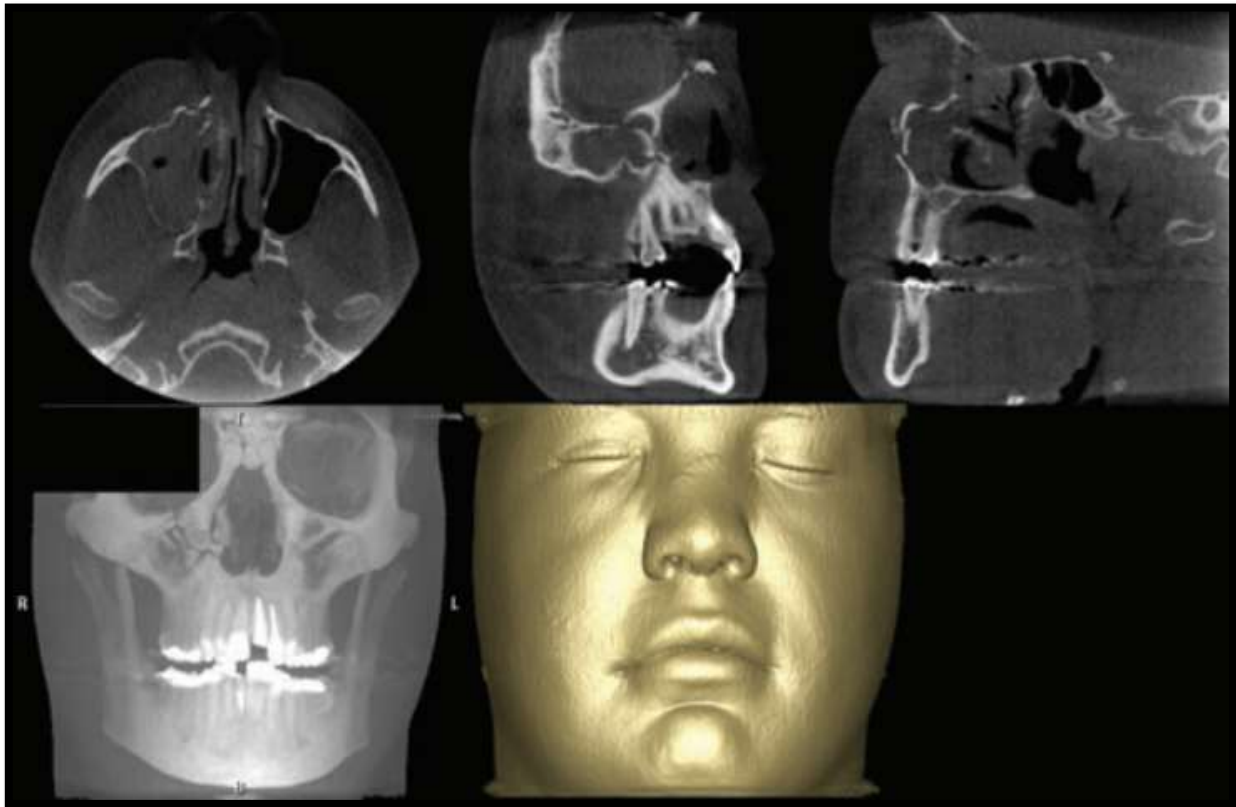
different states of mandible Cone-beam tomography(29).
